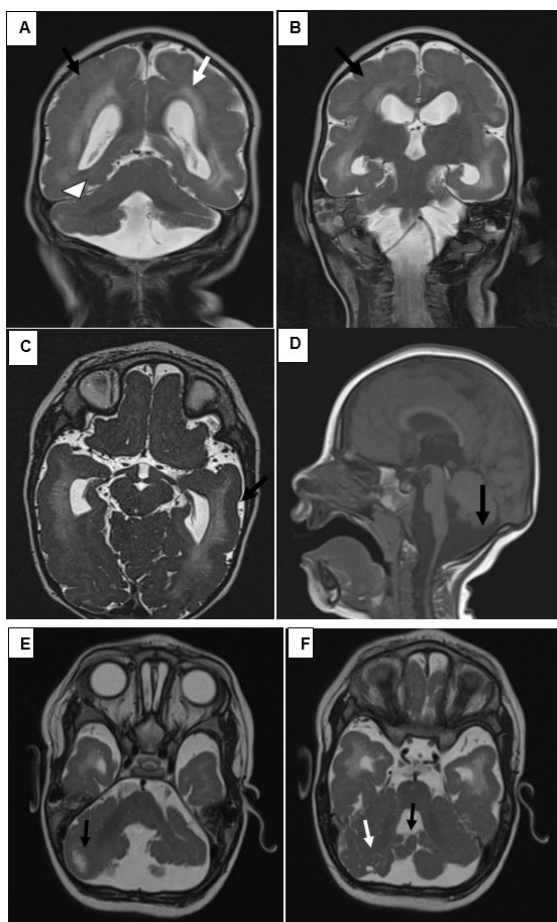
Brain MRI: Coronal (A, B) and 3D axial (C) T2-weighted sequences showing abnormalities of the periventricular white matter (white arrow) with subcortical radial bands in T2 weighted with hypersignal “tigroid pattern” (black arrow), pachygyria (B) and a smooth aspect of the cerebellum (black arrow in (A)). Sagittal T1-weighted sequence showing in (D) enlargement of the great cistern communicating with the fourth ventricle. Axial T2-weighted sequence (E, F) showing dysplasia of the cerebellar hemispheres (white arrow) and of the vermis (black arrow in (F)) with hypersignal of the right cerebellar hemisphere (E).
